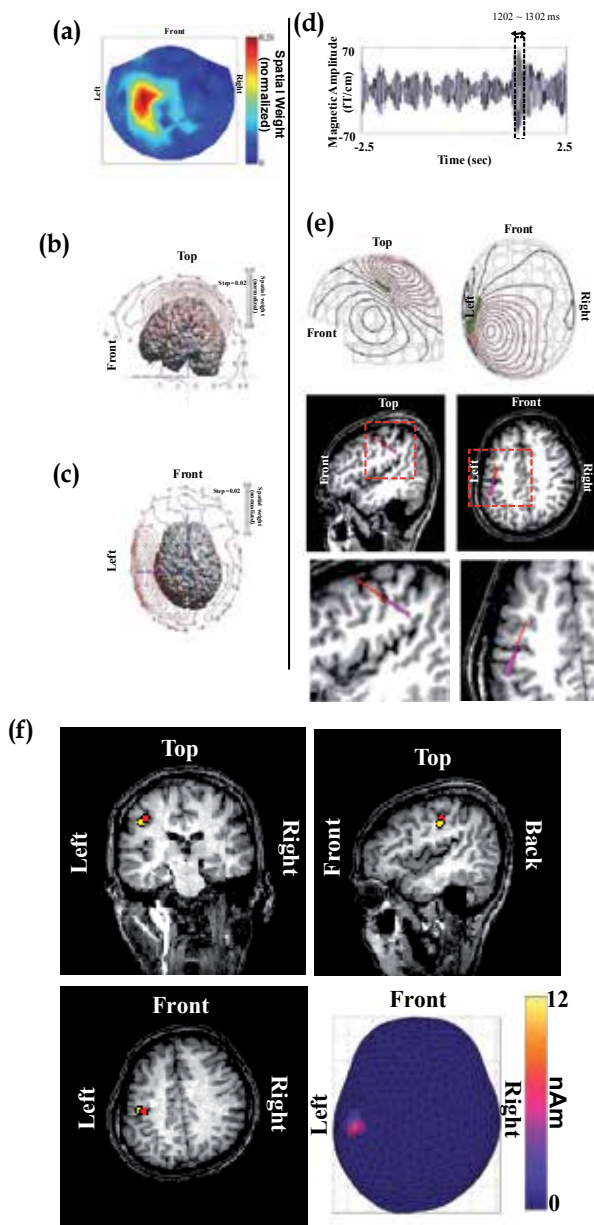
Overlay of extracted reactive beta activities on MR image. (a) Spatial map
